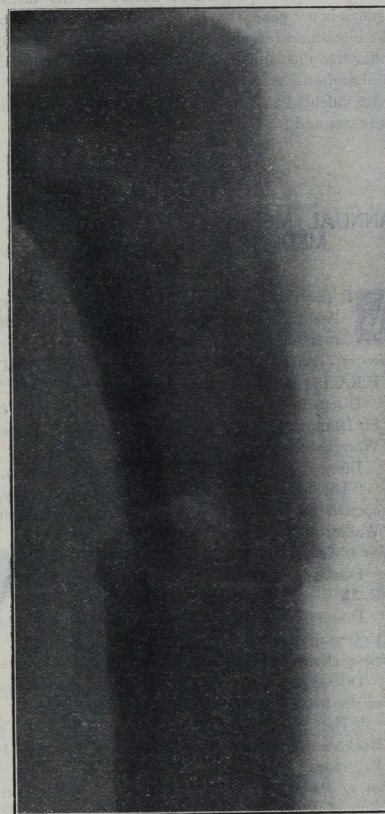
F. R.—. X-RAY TAKEN IMMEDIATELY AFTER FRACTURE.
